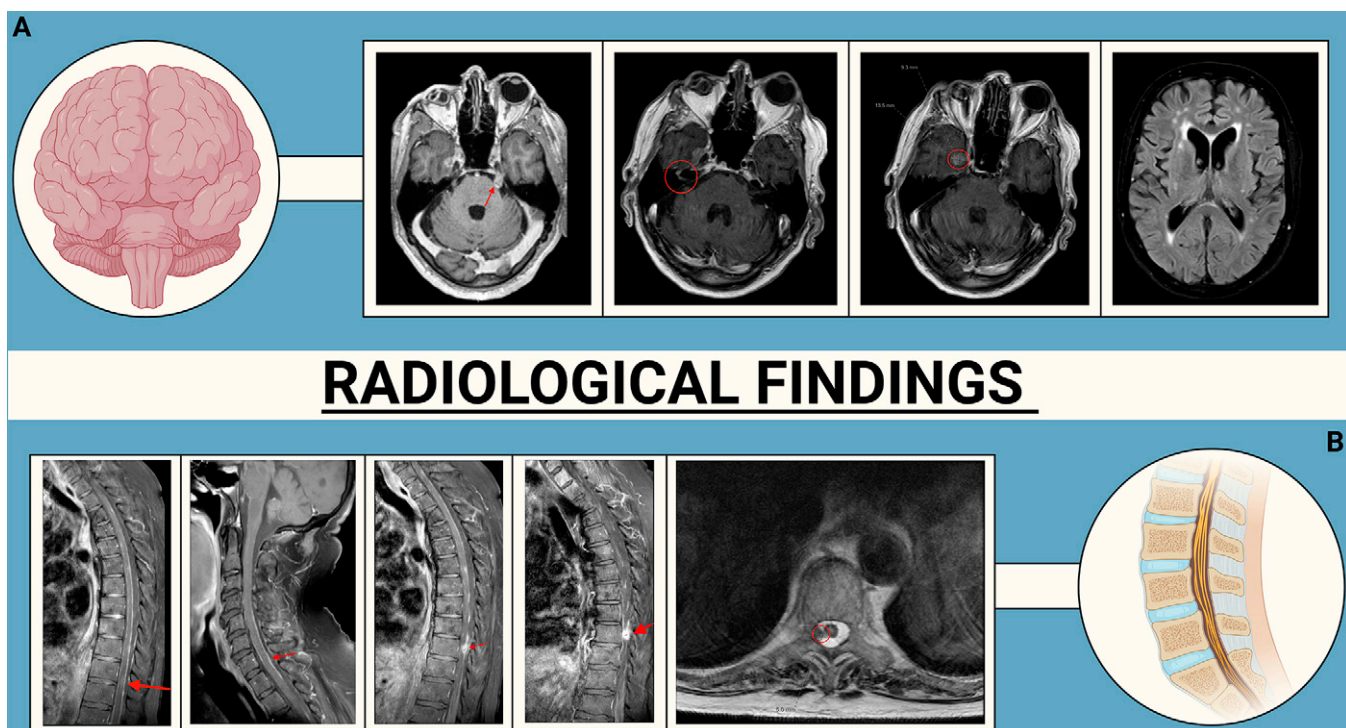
T1-weighted MRI of the brain (A) and spine (B) showcasing (from left to right, red arrow and circles, upper row) abnormal enhancement of the left fifth and right seventh cranial nerves, with extraaxial enhancement in the inferomedial aspect of the temporal lobe adjacent to the cavernous sinus and periventricular leukoaraiosis. MRI of the spine shows diffuse dural enhancement with a ventral intradural-extramedullary nodular enhancement at the thoracic segments of the spinal cord. Created with BioRender.com..
